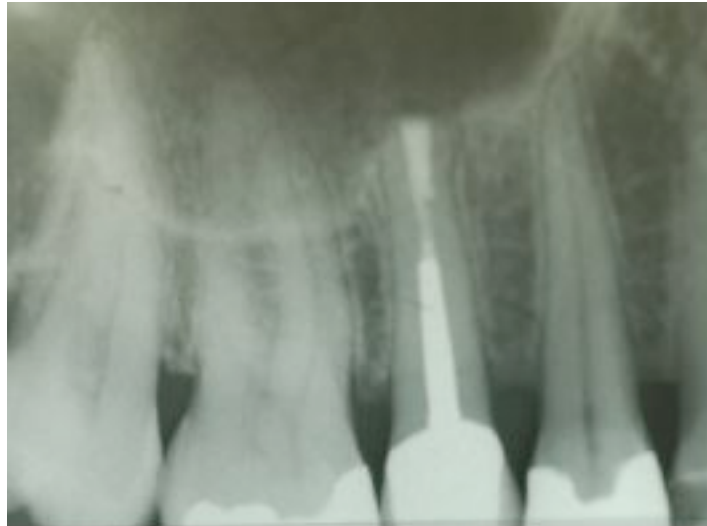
X-ray six months after the operation. Continuous periodontal space apically shows periapical reossification defined to the lumen of the maxillary sinus
